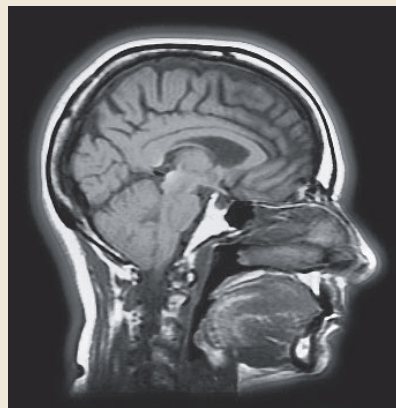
Figure F Magnetic Resonance Imaging (MRI)
